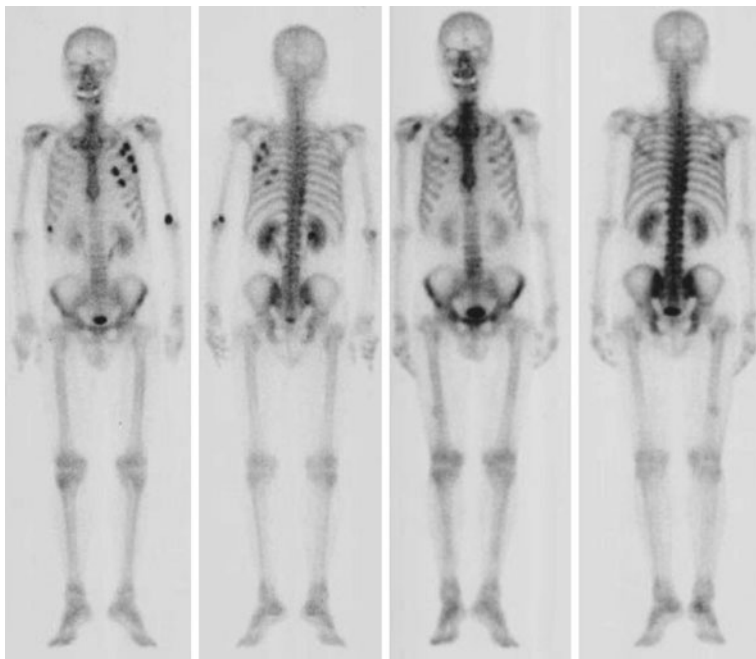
Bone scintigraphy (in this case before and after-treatment bone scintigraphy from Mado et al. 2006, published under Creative Commons license)
